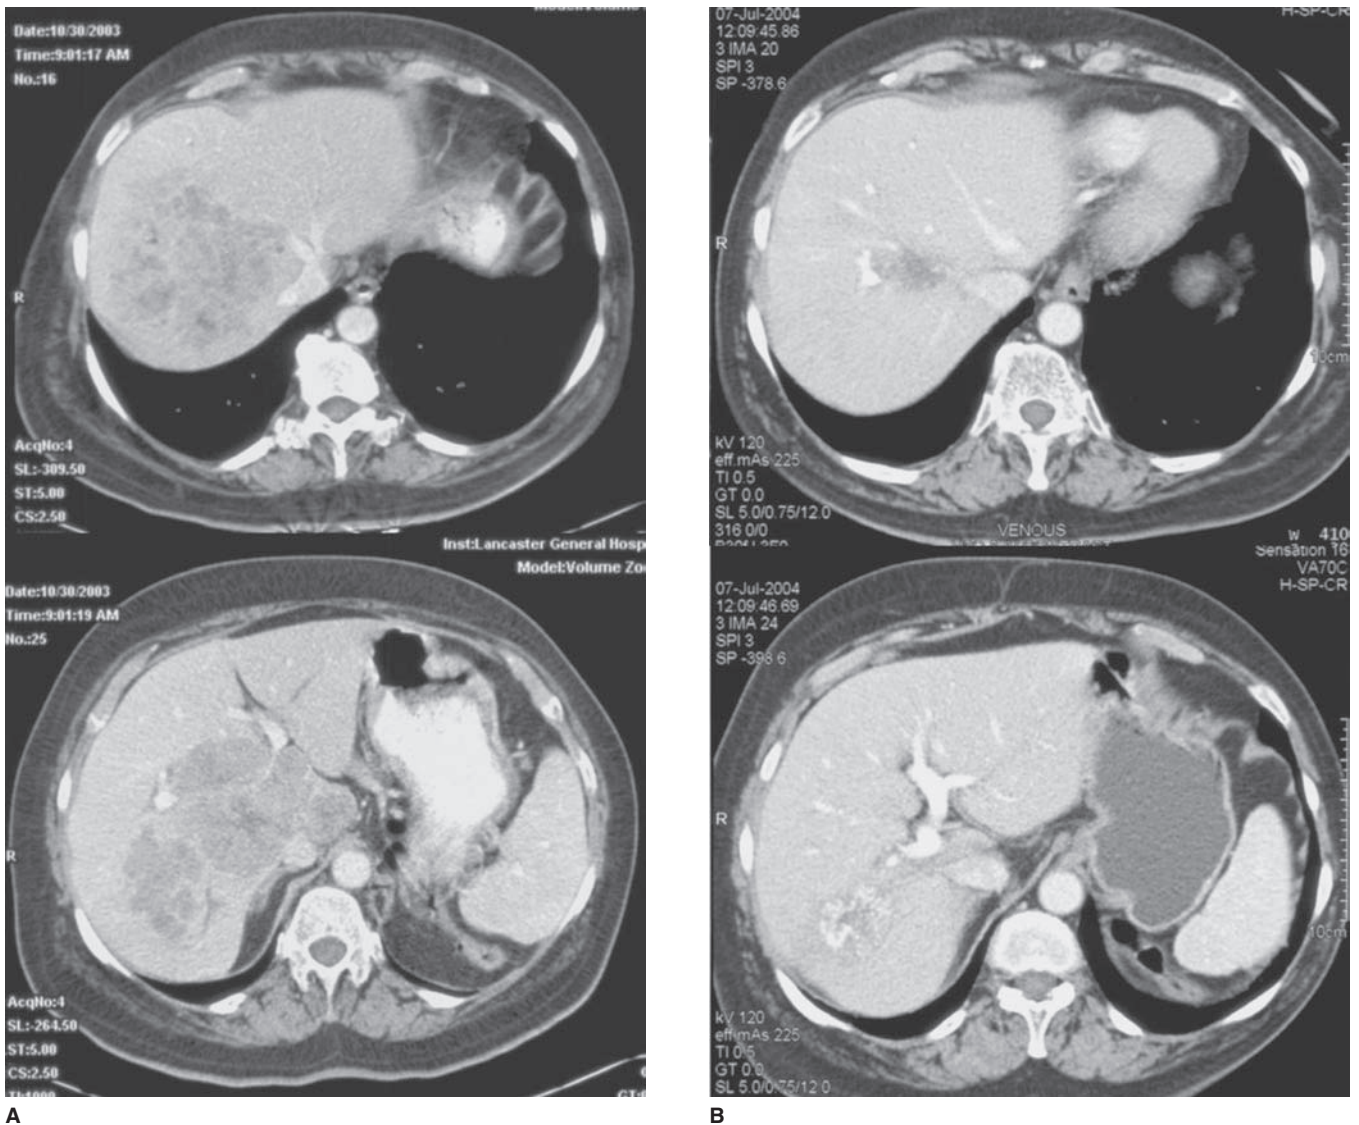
Computed tomographic images in a patient with metastatic colorectal cancer. A. Bulky liver-only disease in patient initially considered unresectable. B. Converted to resectable status following response to preoperative systemic chemotherapy (FOLFOX with bevacizumab).
